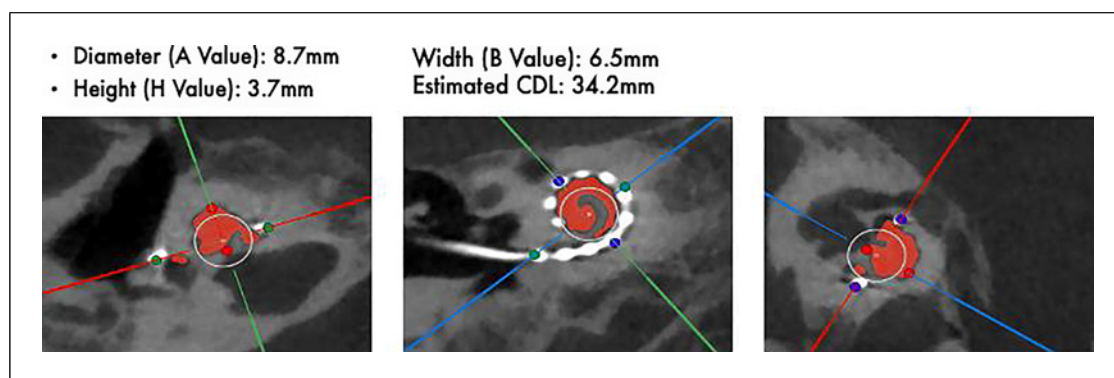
CT analysis by OTOPLAN® to determine the diameter, height, and width of the cochlea for CDL estimation.
